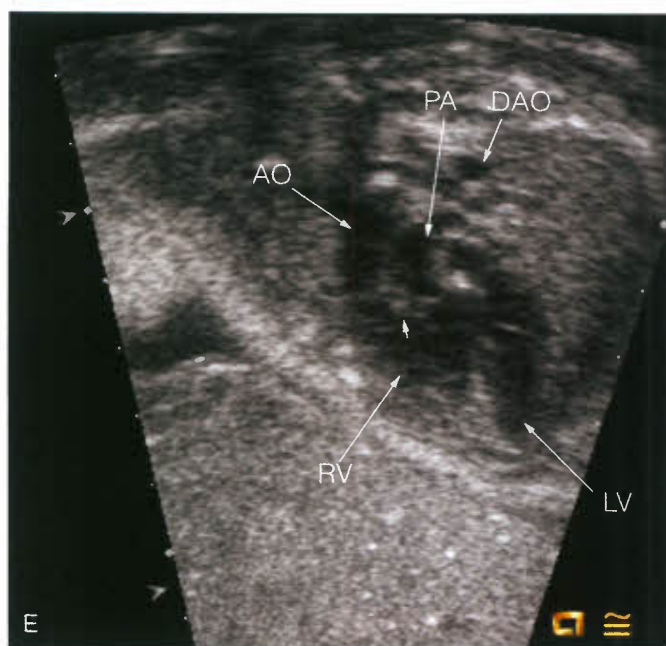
(Continued) E: Fetal echocardiogram in Taussig-Bing heart: Aorta and pulmonary artery both arise from RV, side-by-side with the aorta rightward. Small arrow marks conal septum. RV, right ventricle; LV, left ventricle; AO, aorta; PA, pulmonary artery; DAO, descending aorta.
